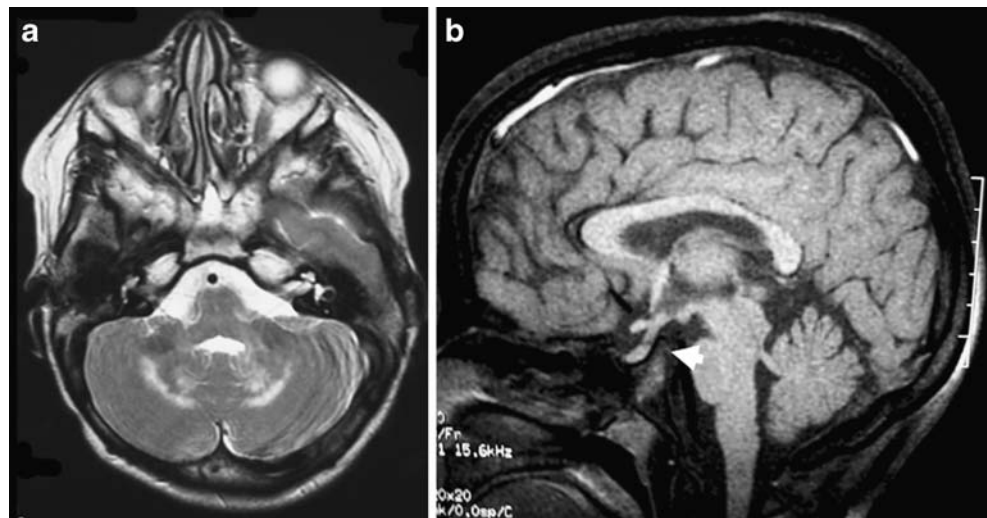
A 4-year-old girl with varicella zoster infection who presented with encephalitis as the skin lesions were crusting. The encephalitis responded to steroids as expected in ADEM. FLAIR
